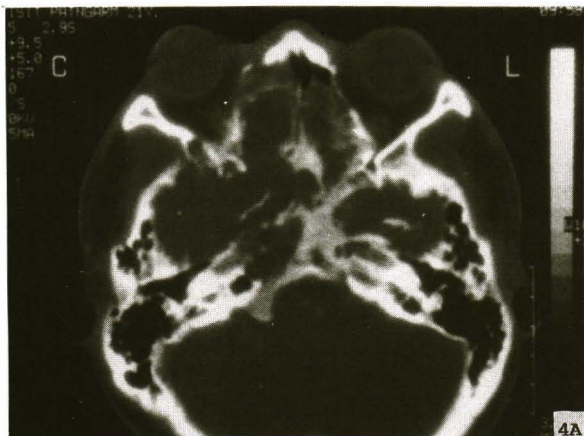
CT scan shows the mass extensively involving the paranasal sinuses, posterior nasal cavity, nasopharynx, and intracranial extension.
